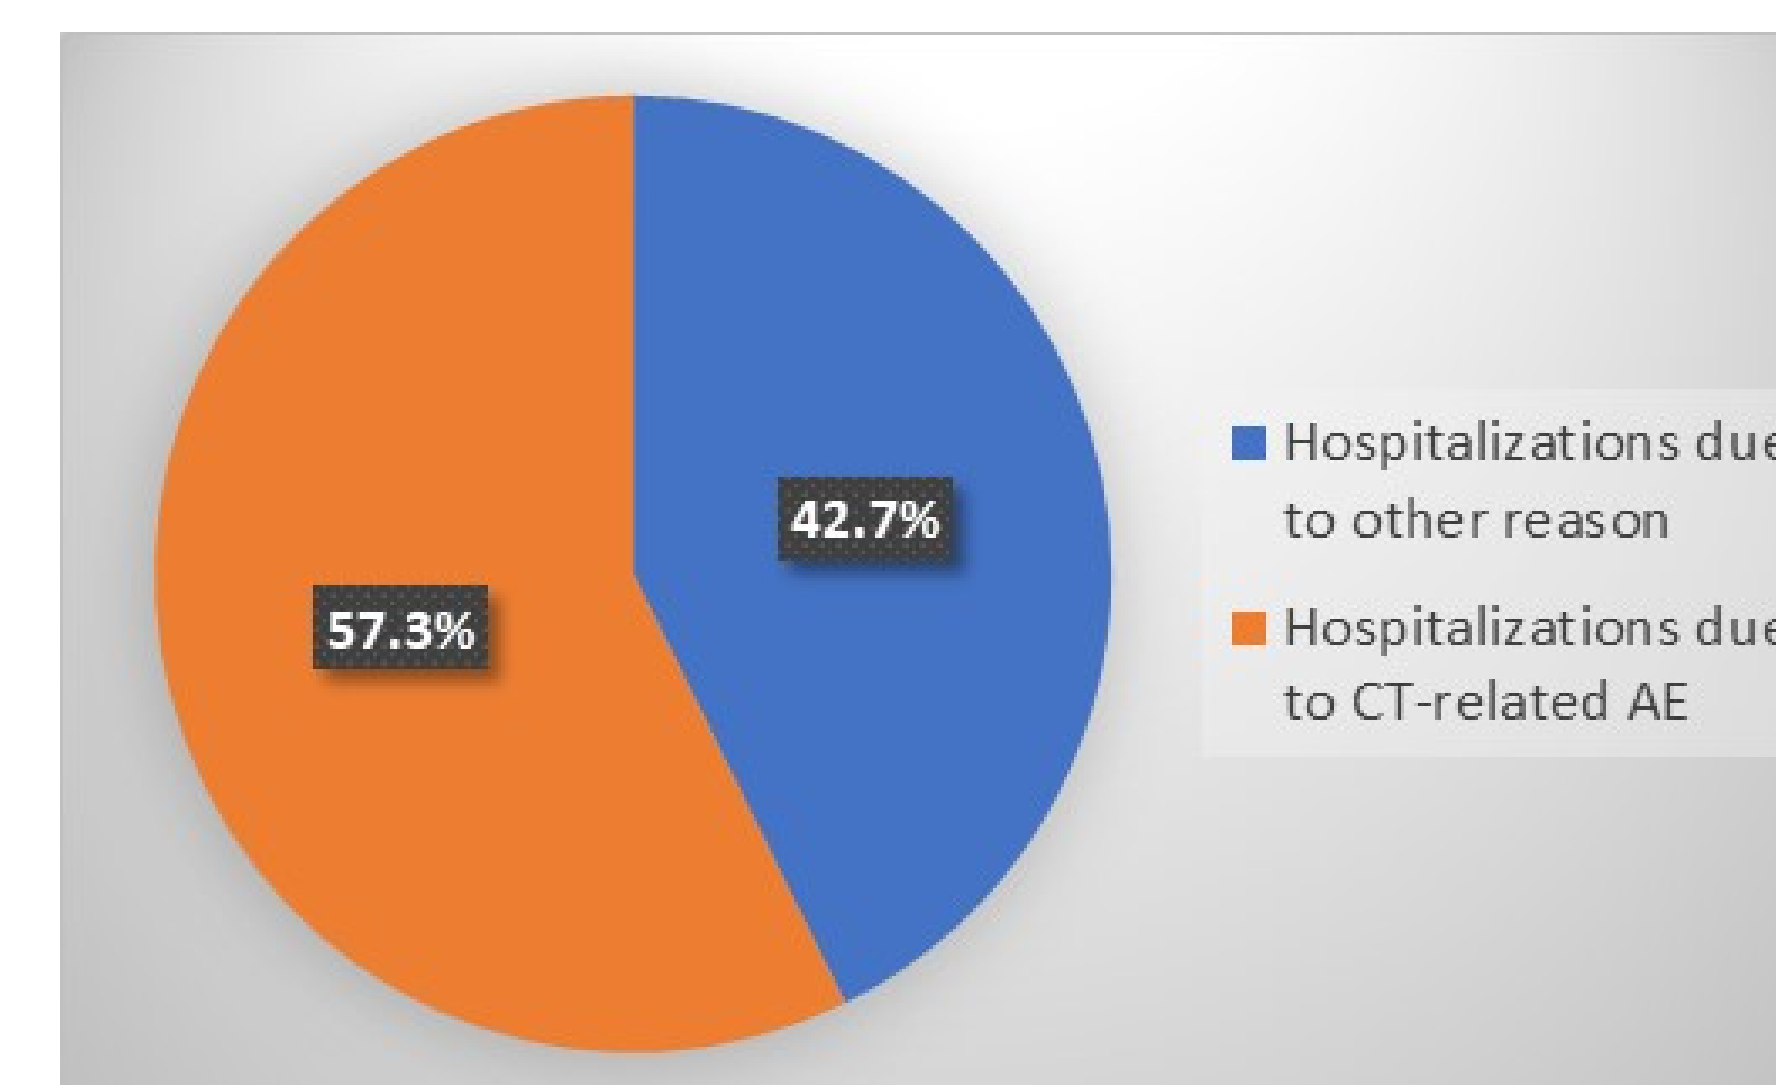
Proportion of hospitalizations due to CT-related AE among patients having at least one AE-related hospitalization
